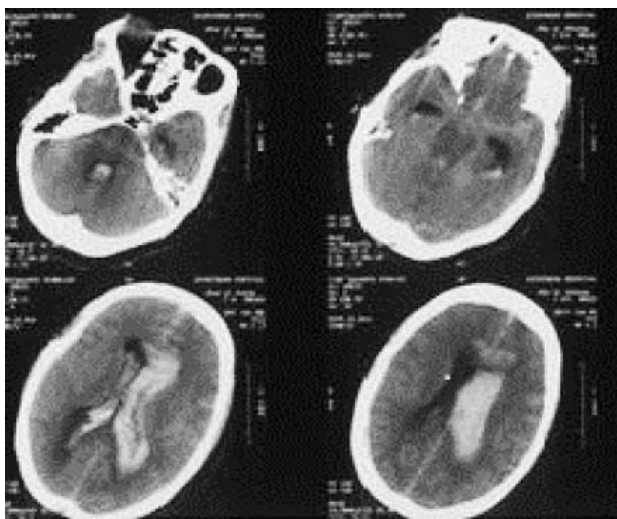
CT image of brain scans of a patient with intraventricular hemorrhage. The results revealed IVH-induced acute hydrocephalus and diffusive brain edema.
